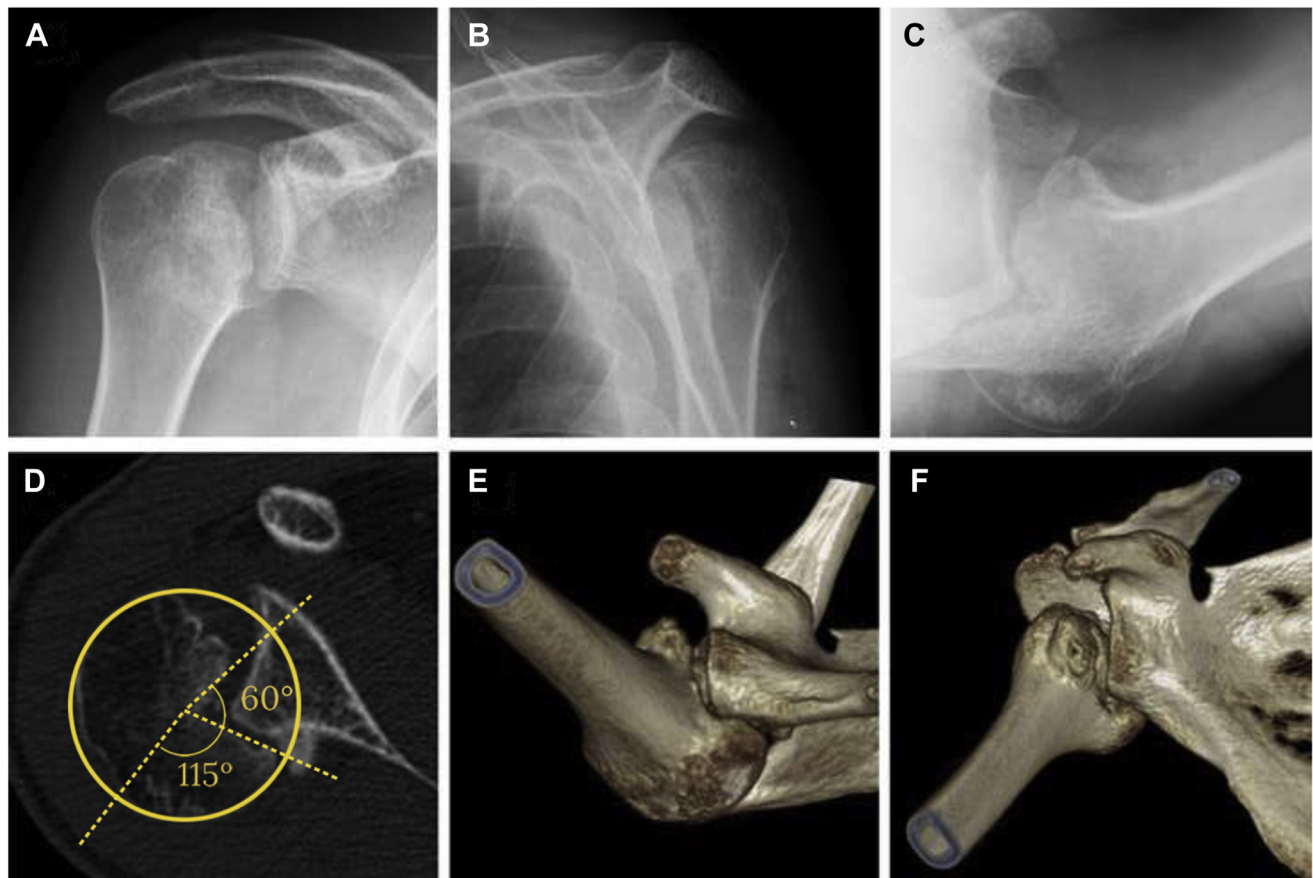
(A-C) Preoperative radiographs of the right shoulder of a patient with a 6-week delay from injury to diagnosis showing a chronic locked posterior dislocation of the shoulder with a large reverse Hill-Sachs lesion. (D) The defect size is calculated on an axial 2-dimensional computed tomography image, according to Gerber et al.¹⁹ The percentage of the cartilage angle (175° in this case) that the defect angle (60° in this case) represents is the estimated size of the defect (34% in this case). (E, F) Three-dimensional computed tomography reconstruction images of the same patient.
